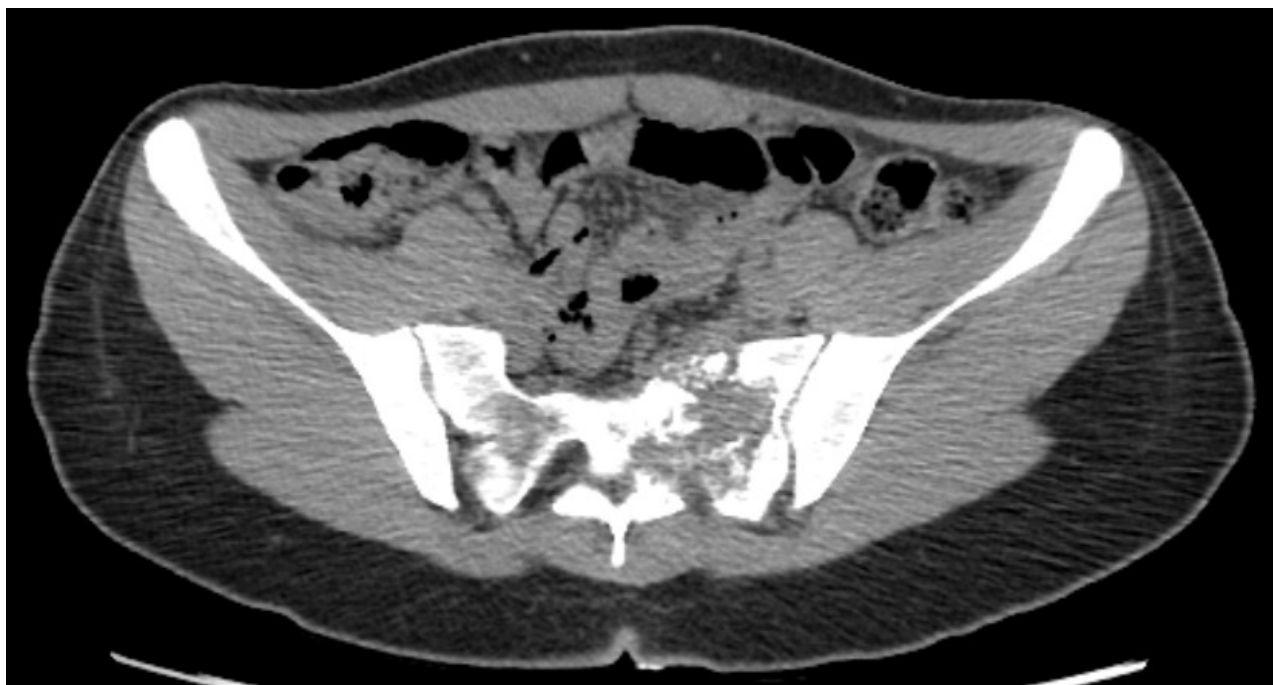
Case 1. Sacral capillary hemangioma. Preoperative CT scan. Note the presence of an isodense mass in the left hemi-sacrum with osteodestructive with extension to the ipsilateral sacroiliac joint without interruption of the bone cortex at the level.
